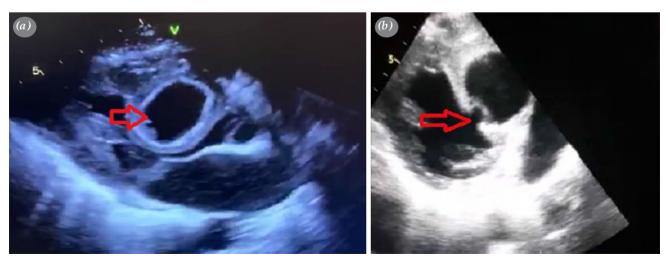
(a) Diagnosis of cardiac hydatid cyst by echocardiography. (b) Demonstration of ruptured cardiac hydatid cyst by bedside echocardiography.
